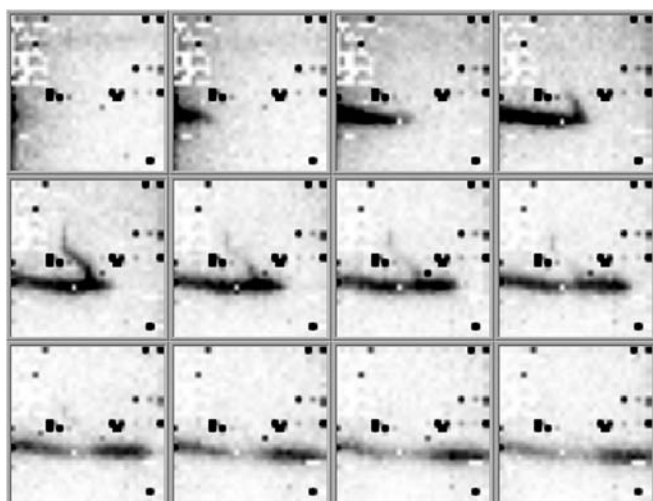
Dynamic images of blood flow in the forearm of a patient who underwent bone scintigraphy. The serial images clearly display the blood flow of ^{99m}Tc -MDP in the median cephalic vein. Note the small ramification vessel from the vein
